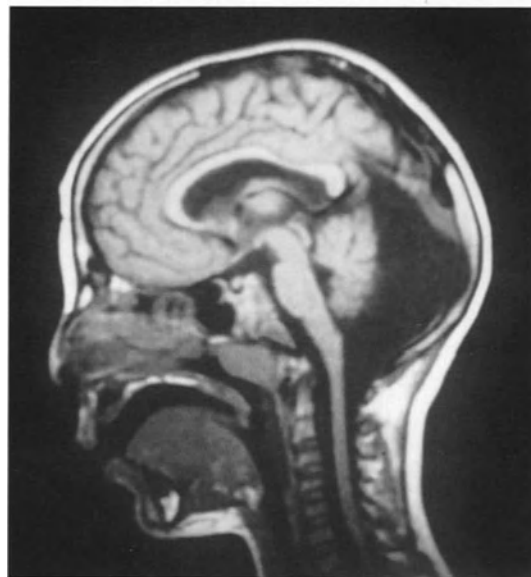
This is a sagittal cranial MRI T1 weighted image, in a child with congenital meningomyelocele, with no hamartoma present. A most unusual observation is what we see here: no Chiari II, cystic transformation of the cisterna magna, and hypotrophy of the cerebellum.
